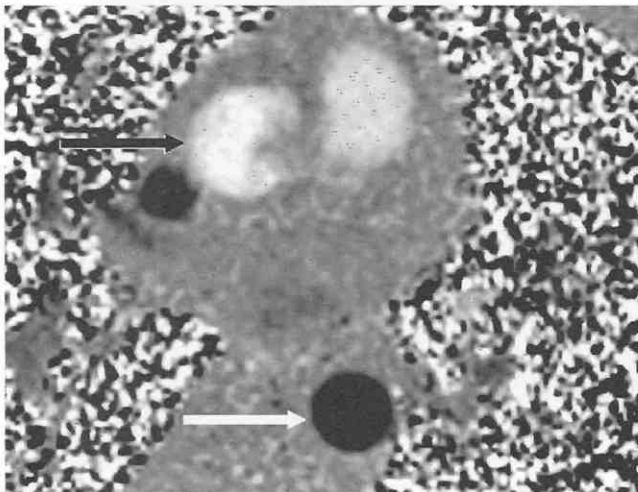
Phase-contrast MR image at the level of the mid-thoracic aorta shows cephalad blood flow displayed in white (black arrow), and caudad blood flow in black (white arrow).
